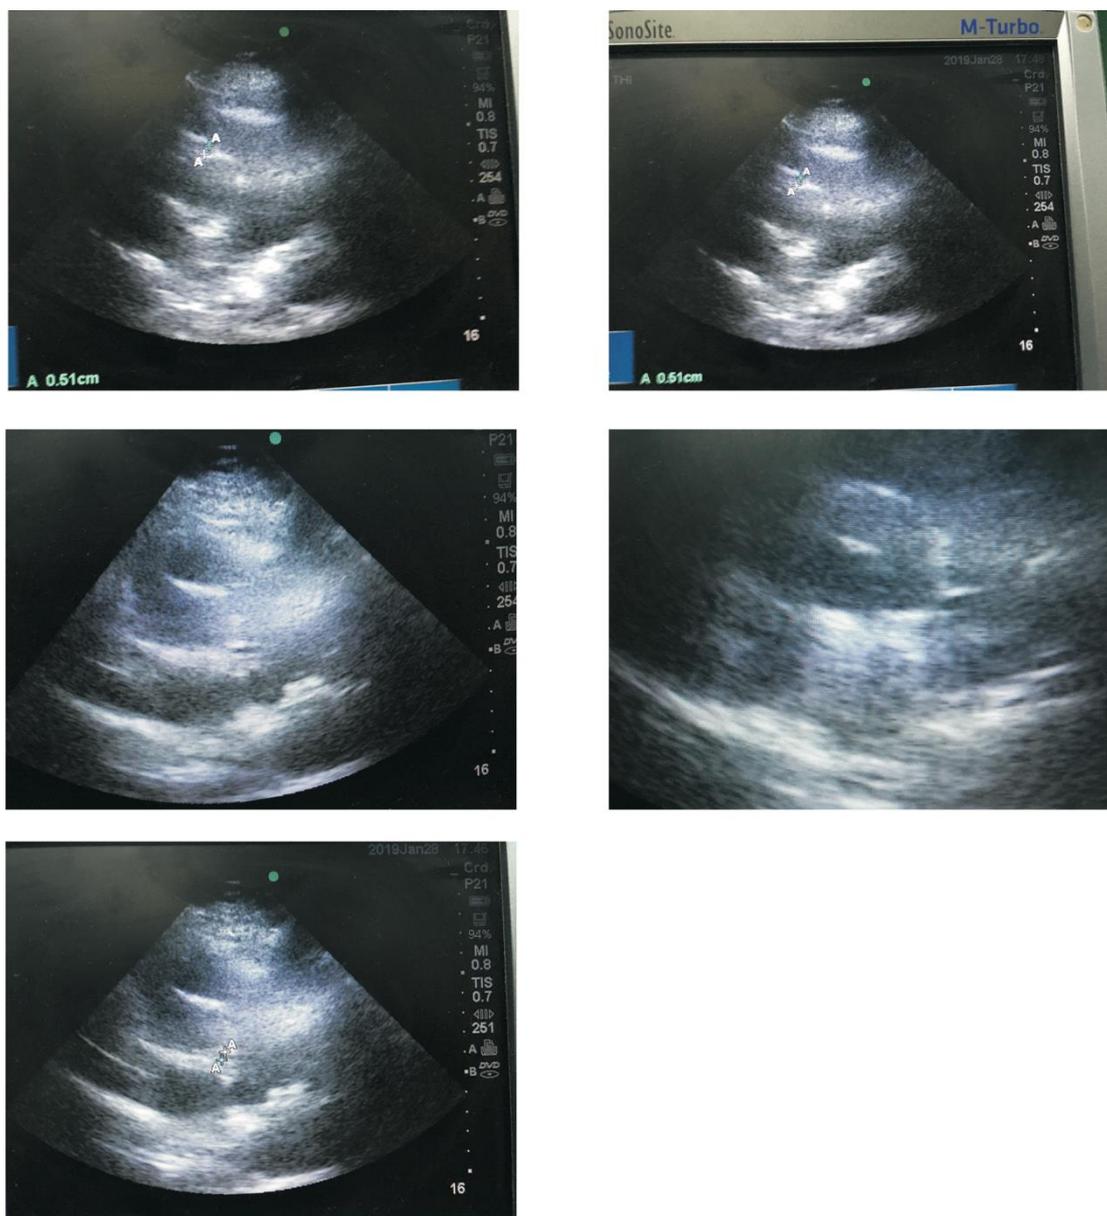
The echocardiographic pictures (short axis view) of some control patients and their coronaries.
